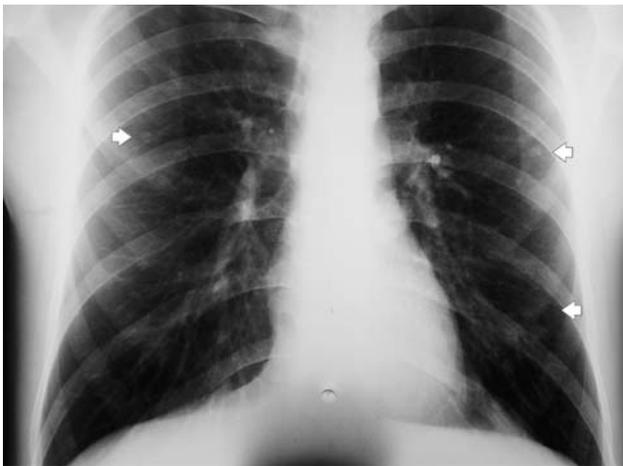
Standard chest X-ray examination: presence of a roundish, opaque area of tenuous density in the anterior mediastinal part on the anterior edge of the right ventricle and multiple nodular lesions.
